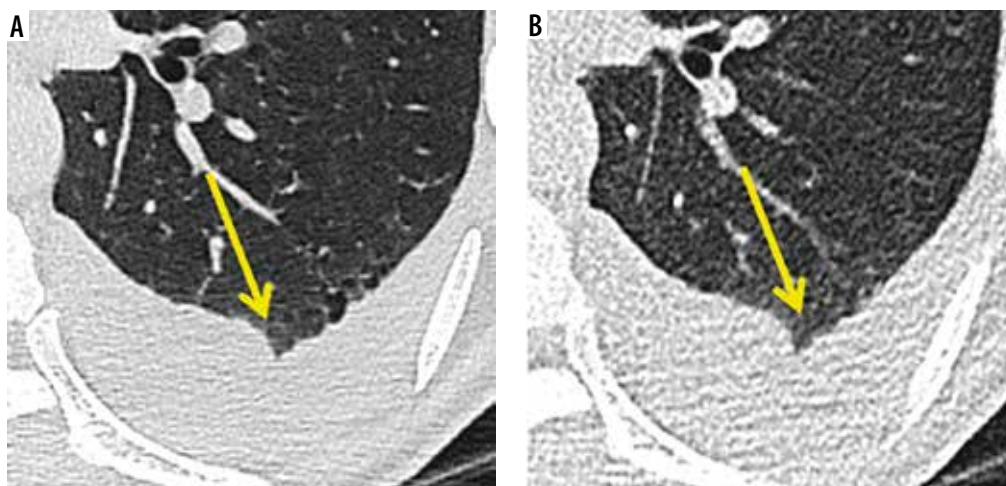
Axial sections of computed tomography (CT) showing detectability of solid pulmonary nodule (yellow arrow) by ultra-low dose CT. Solid pulmonary nodule was well seen on both standard and ultra-low dose CT scans
